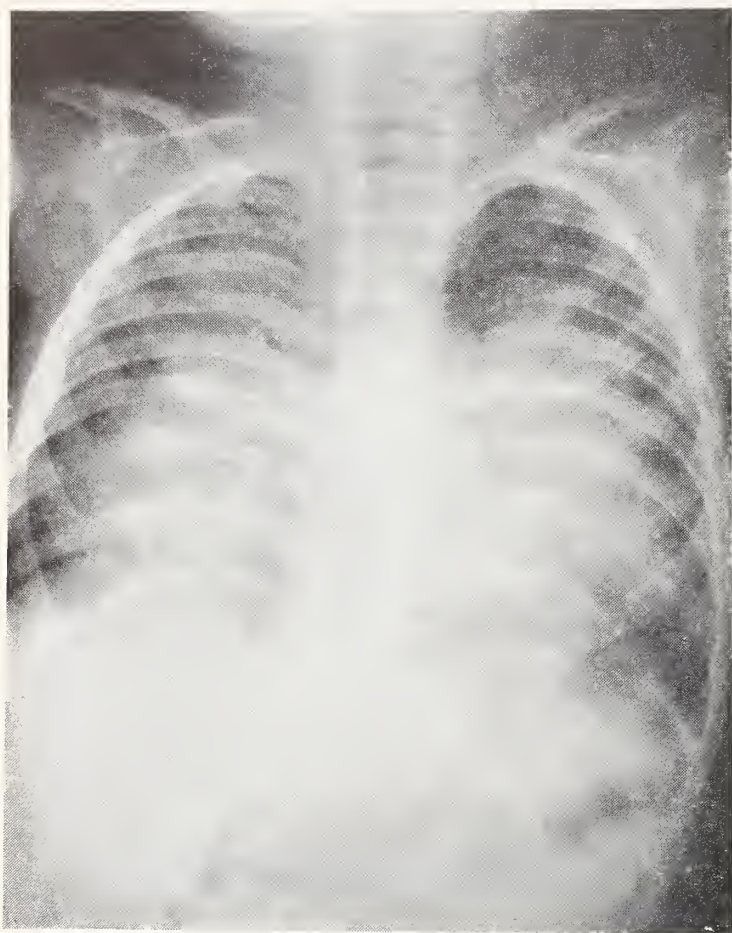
Chest radiograph taken about 15 hours after ingestion of several ounces of liquid red furniture polish.
